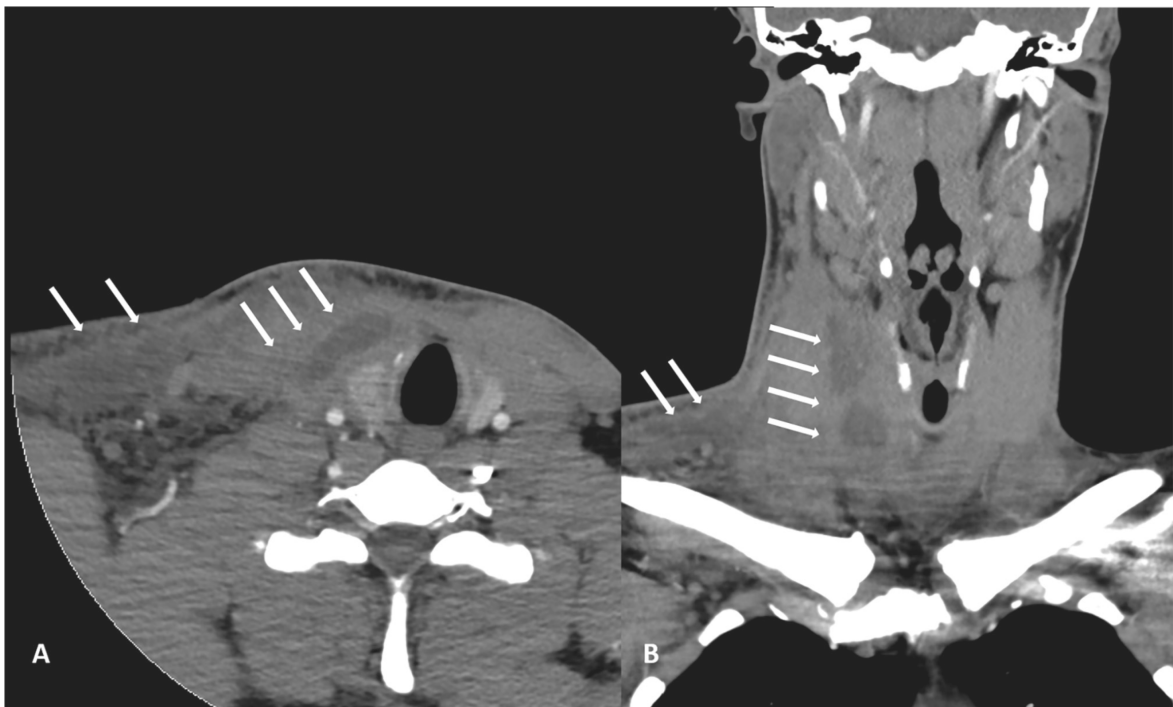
Contrast-enhanced computed tomography of the neck, showing large confluent central hypodense contrast formation (arrows) starting from the right thyroid lobe and extending to the subcutis ventral of the sternocleidomastoid muscle in axial (left) and frontal (right) orientation. Figure originally published in Trummer et al. [2] under the CC BY license.
